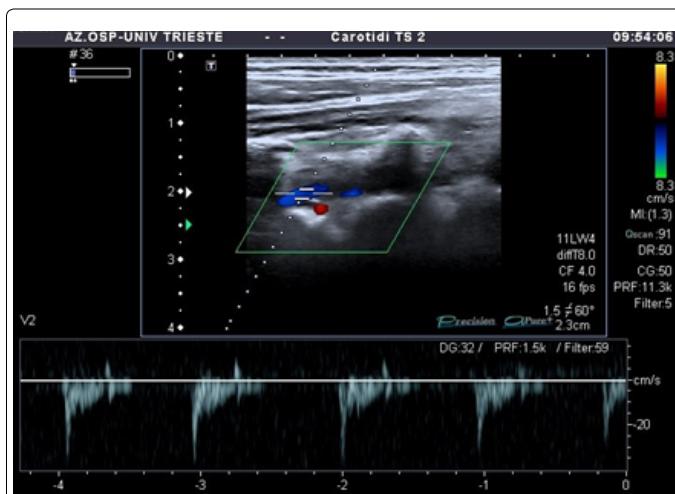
Color-duplex ultrasound, B mode examination, showing left vertebral artery with hypoechoic vessel wall with abnormal flow such as color aliasing, flow demodulated with minor systolic picks (VPS 27 cm/s) and none diastolic picks.
